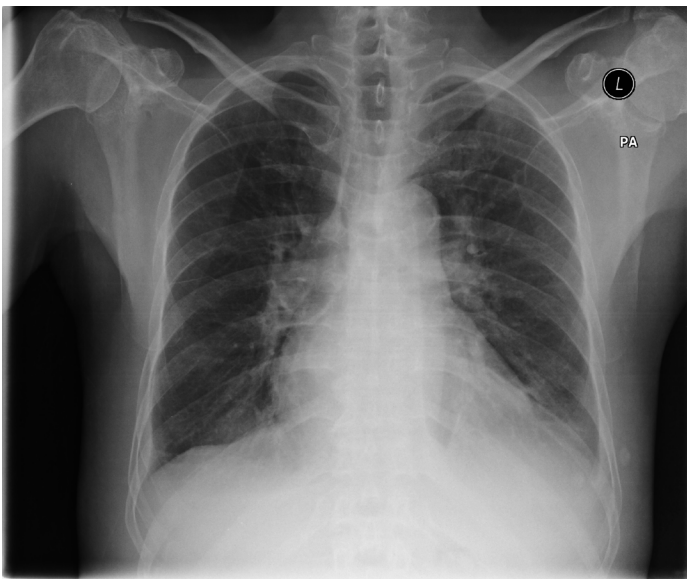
Norma PA Chest X-ray on admission.
